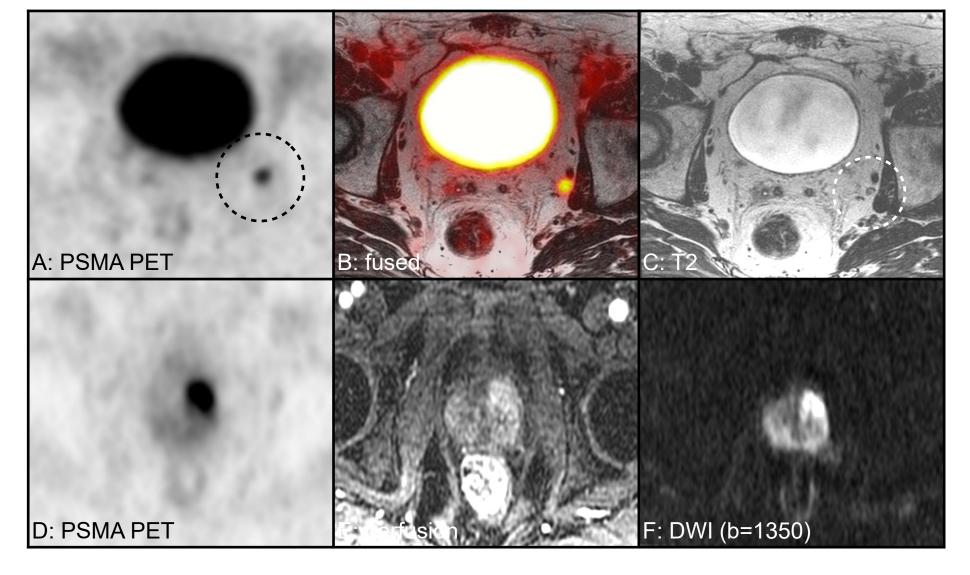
69 year old man with Gleason 5+4 on biopsy, PSA of 18.5. PSMA PET demonstrated multiple left obturator and pelvic side wall nodes, which was confirmed at time of prostatectomy.
